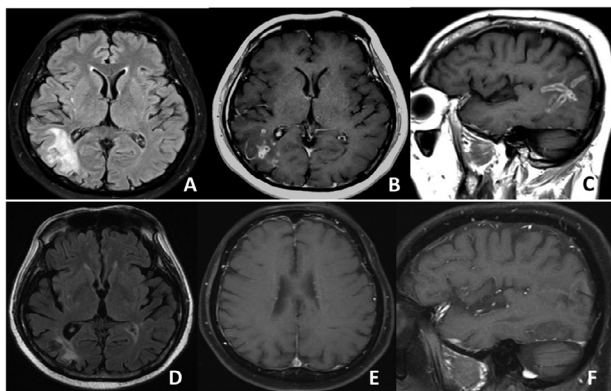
The brain MRI of the first patient: (A) axial fluid-attenuated inversion recovery (FLAIR), (B) axial, and (C) sagittal post-contrast T1-weighted (T1W) revealed tract-like enhancing lesions at the right parietotemporal lobe with surrounding vasogenic brain edema. (D) Axial FLAIR, (E) axial, and (F) sagittal post-contrast T1W of the follow-up MRI after complete treatment showed improvement and no area of residual enhancement
